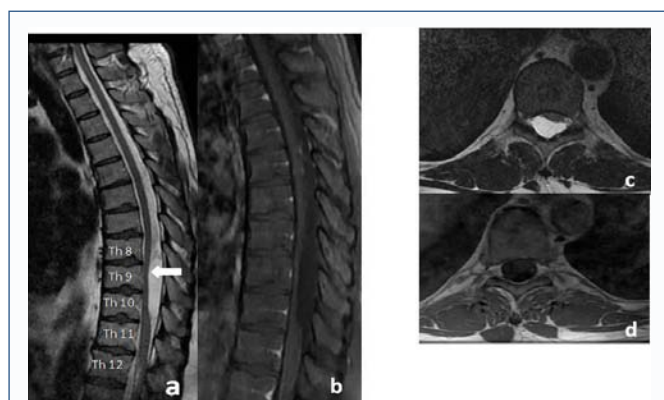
The patient's preoperative Magnetic Resonance Imaging (MRI) demonstrates the following findings: (a) On the T2-weighted sagittal image, a purely cystic lesion is observed, displacing the spinal cord anteriorly (white arrow indicates the lesion), (b) On the contrast-enhanced T1-weighted sagittal image, the lesion appears isointense with Cerebrospinal Fluid (CSF) and shows no contrast enhancement, (c) On the T2-weighted axial image, anterior displacement of the spinal cord is clearly evident and (d) On the contrast-enhanced T1-weighted axial image, the lesion is again isointense with CSF and demonstrates no contrast enhancement.
